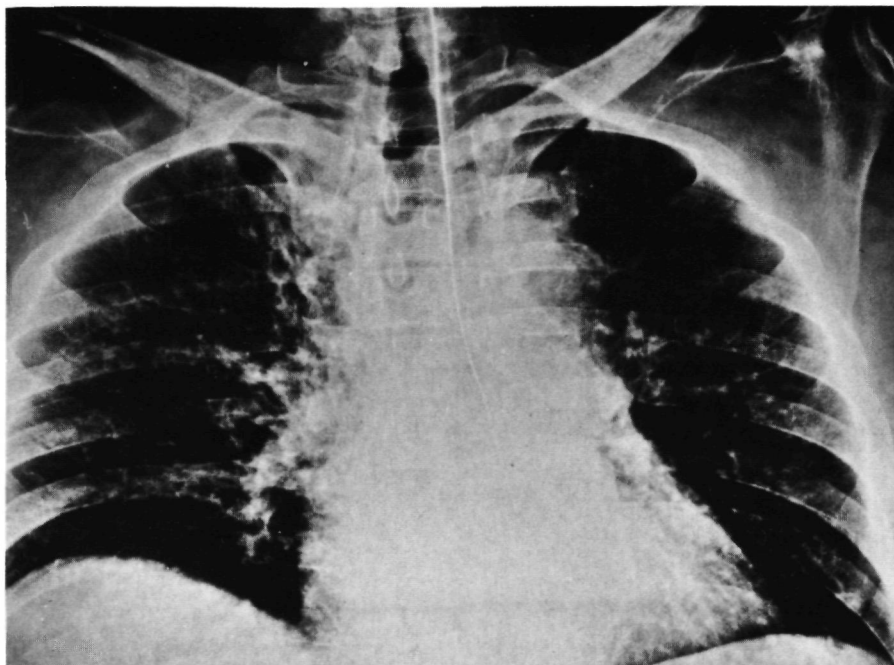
7 Male, 59 years, vertical deceleration (suicide attempt), TAR. Uneventful recovery after operation. Chest X-ray: normal position of trachea and nasogastric tube. Widening of the mediastinal shadow (10 cm). Unsharp aortic outline. Opacified pulmonary window.
